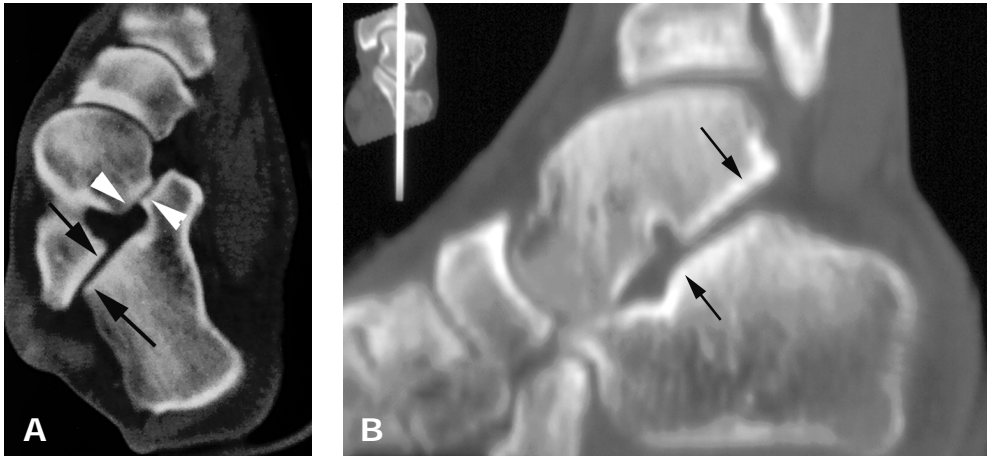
A, Axial CT section during inversion stress. Subluxation in the posterior (arrows) and middle subtalar joint (arrowheads). B, Sagittal CT reconstruction of the subluxation in the talus and calcaneus (arrows).
